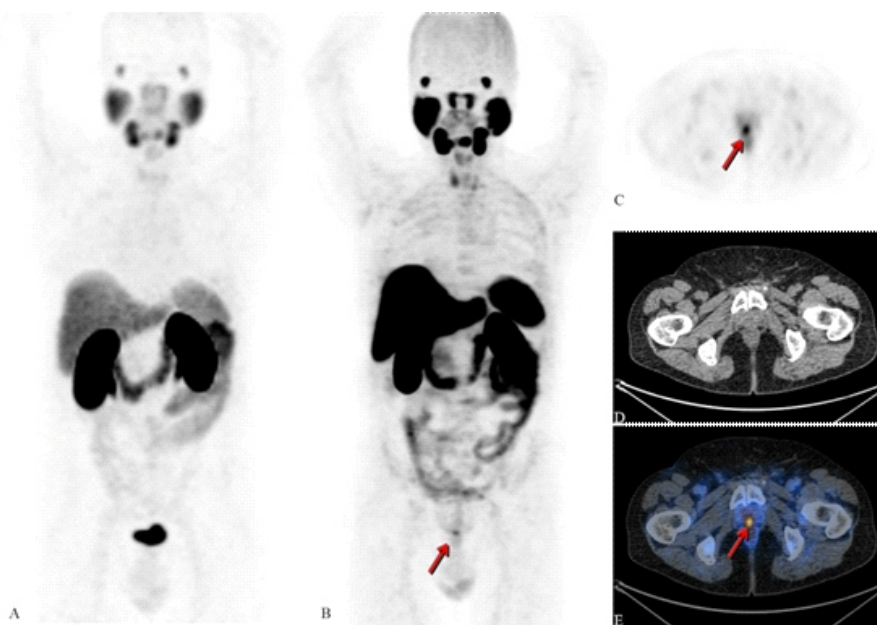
Patient treated with radical prostatectomy in 2004 due to adenocarcinoma of the prostate and salvage radiotherapy after biochemical relapse in 2007 with negative restaging. In 2013, new biochemical relapse with negative restaging (CT, MRI and bone scintigraphy, not shown) treated by intermittent androgen-deprivation therapy. Patient referred for ^{68}Ga -PSMA-11 PET/CT in 2016 (not shown) and 2017 (maximum intensity projection (MIP); A) without any findings (PSA levels at 0.8 and 1.0ng/mL, respectively). Due to further increase of PSA (1.1ng/mL) an ^{18}F -PSMA-1007 PET/CT examination was carried out in 2018. Images B - E show ^{18}F -PSMA-1007 PET/CT of the same patient (B: MIP, C: axial cross section PET, D: axial cross section CT, E: fused axial PET/CT image). Arrows show unequivocal focal uptake representing a local recurrence, with significant contrast, with no distracting ureteral or vesical excretion activity (as compared to A).
